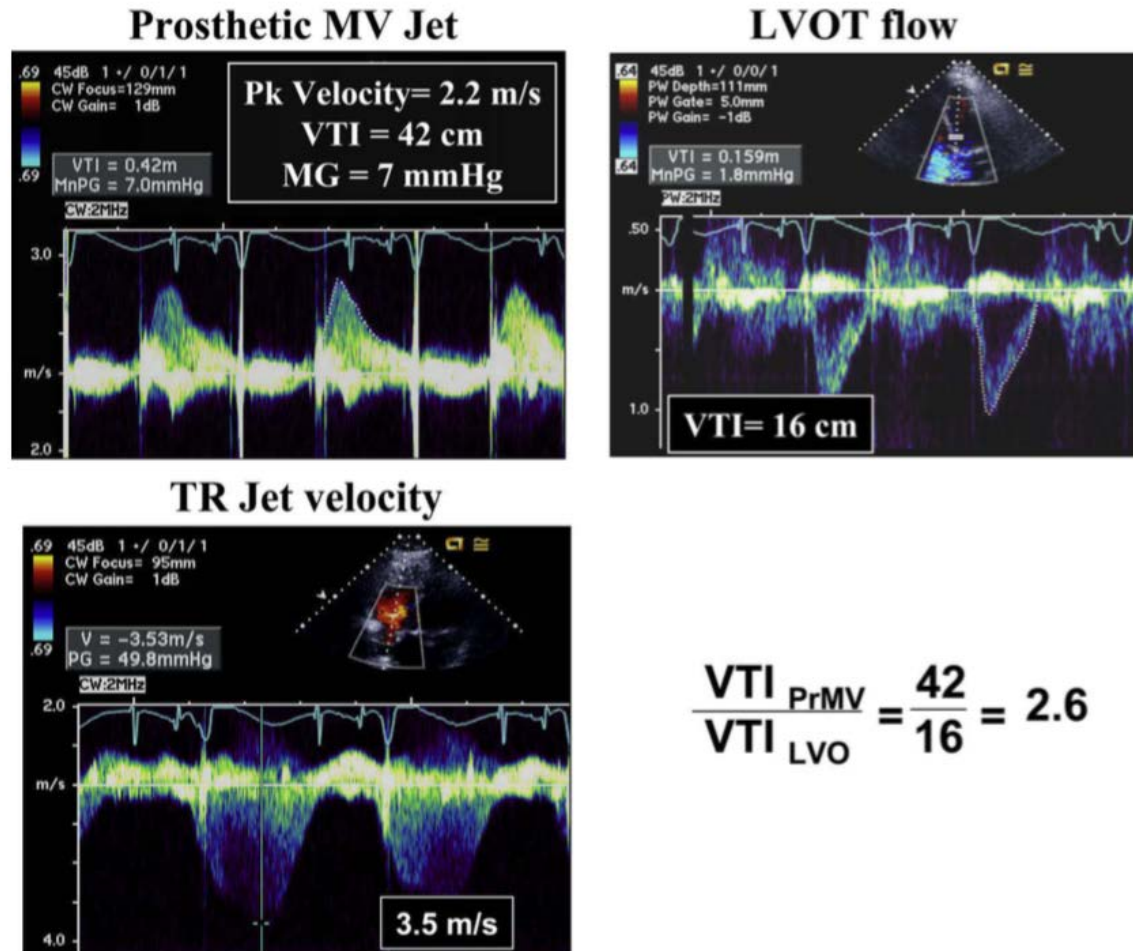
Transthoracic Doppler echocardiographic clues for significant mechanical MR. These recordings are for the same patient
